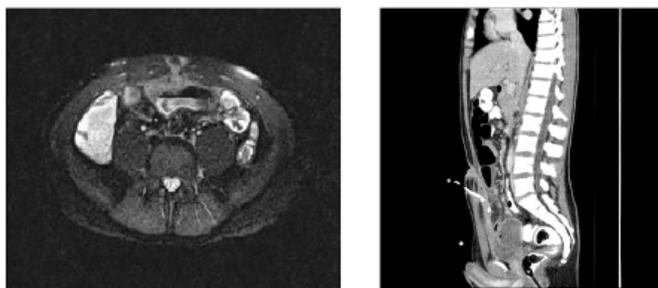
MRE and CT of abdomen/pelvis with contrast. Lobular 6.2 x 4.8 x 9.8 cm peripherally enhancing collection in the anterior pelvis extending from the dome of the bladder, extending to the anterior abdominal wall, and communicating centrally with the umbilicus.
